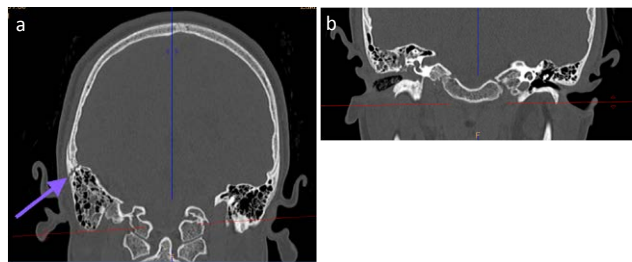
CT scan, coronal plane: fracture of the squamous part (a) and the pyramid of the right temporal bone involving: mastoid process, walls of the tympanic cavity and external ear canal (b). As a result, the right tympanic cavity (called hemotympanum; b) and right mastoid air cells are filled with blood (radiologically seen as impaired aeration of the mastoid process; a, b) (own clinical material)
